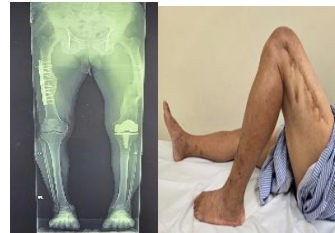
Postoperative xray and scannogram revealed restoration of joint line and mechanical axis
